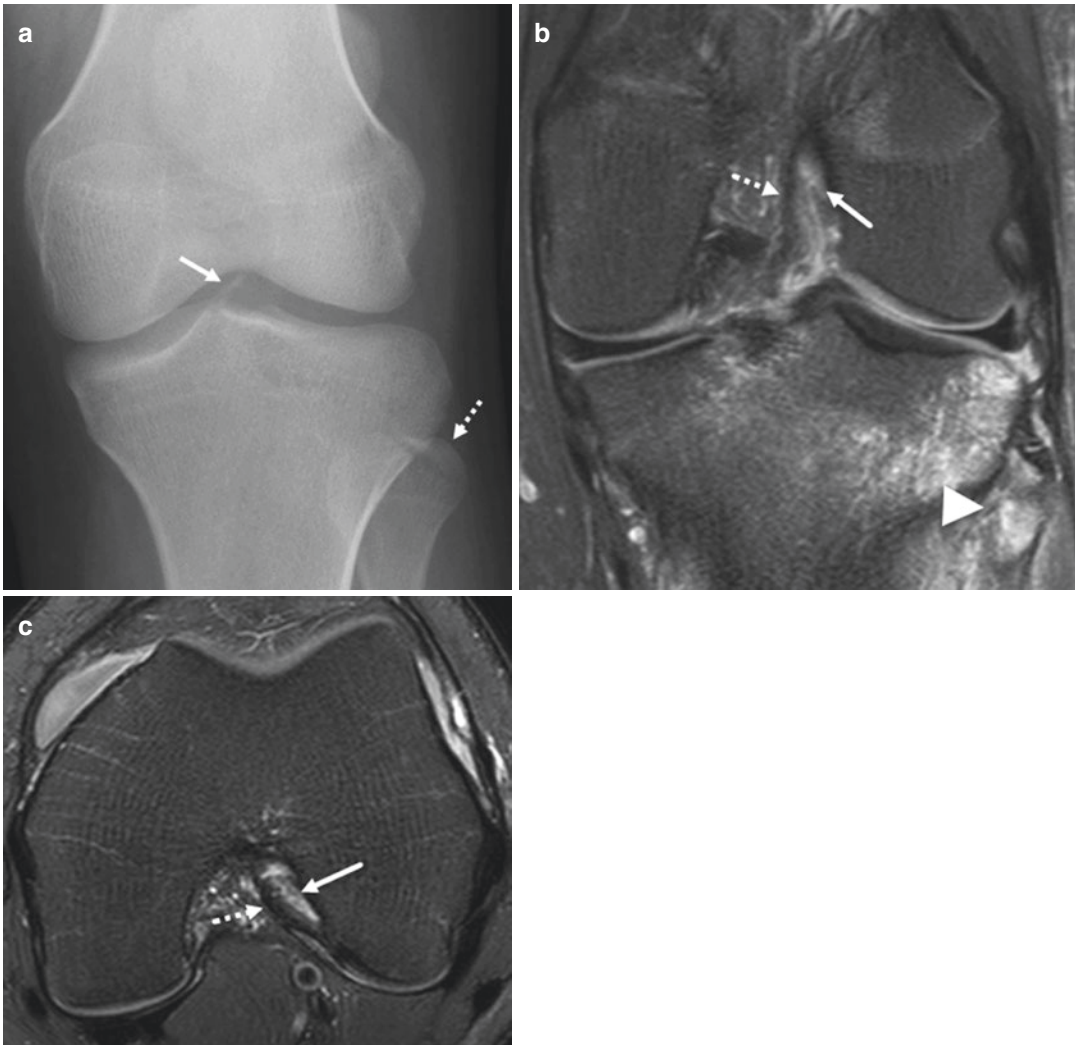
(a) Anteroposterior radiograph of the left knee from a 14-year-old girl shows a tibial eminence avulsion fracture (*arrow*) as well as an avulsion fracture at the fibular head (*dashed arrow*). (b) Coronal T2-weighted fat-suppressed image in the same patient reveals a complete tear of the posterolateral bundle (*arrow*). The anteromedial bundle (*dashed arrow*) is wavy in contour and was
